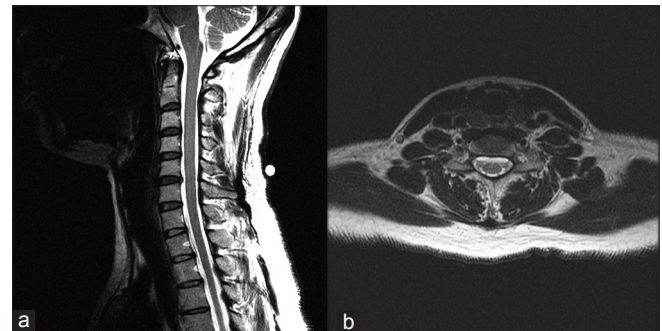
Six-month follow-up T2-weighted (a) sagittal and (b) axial cervical MRI renderings with interval decrease in ventral C6 epidural fluid
